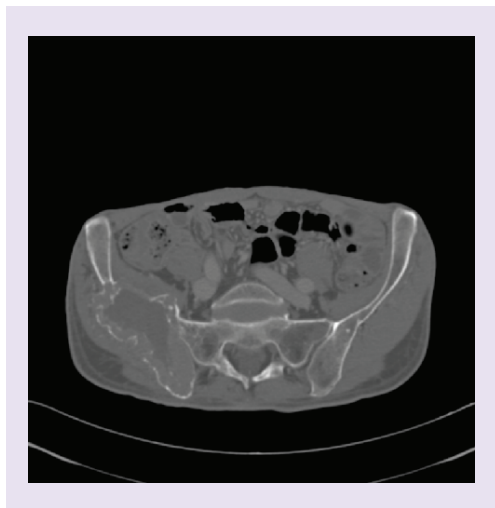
CT scan prior to embolization demonstrates a large locally invasive mass of right iliac bone.
